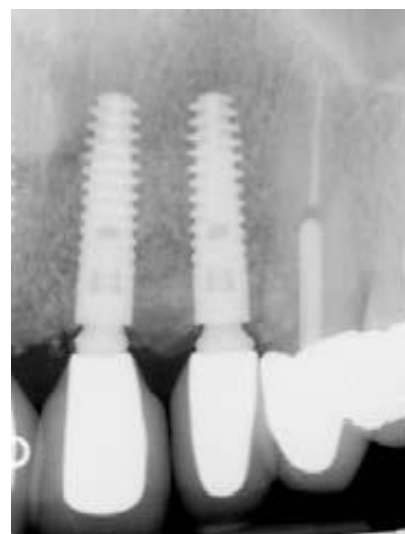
Postoperative radiograph showing multiple implants. This is key to good aesthetic outcome.
